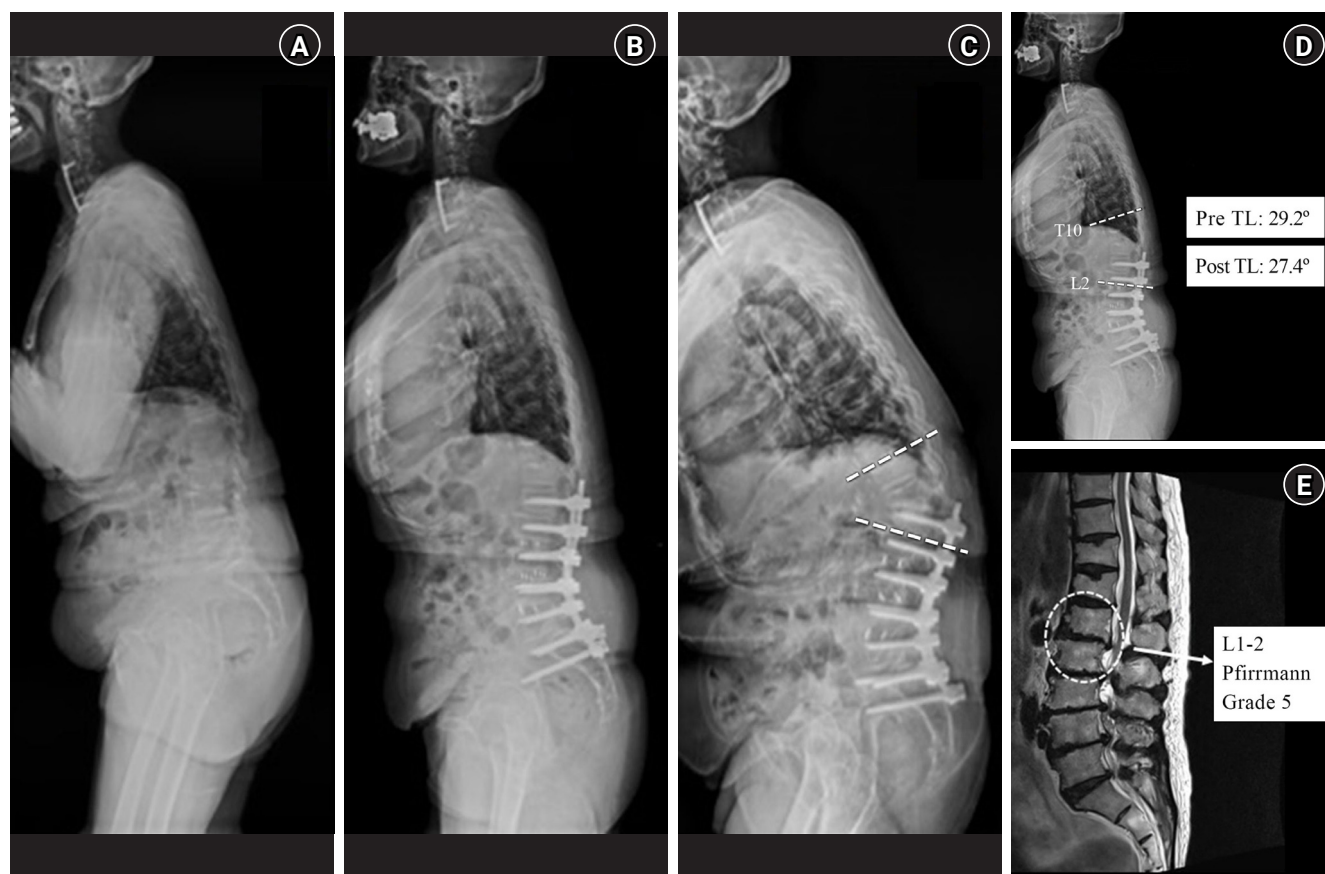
Representative case of early proximal junctional kyphosis (PJK) in a 72-year-old woman with a stooping gait. (A) Preoperative standing lateral radiograph demonstrating degenerative flatback deformity. (B) Immediate postoperative radiograph following multi-level thoracolumbar fusion. (C) Follow-up radiograph obtained 3 months postoperatively demonstrating early PJK, with dashed lines indicating the increased proximal junctional angle. (D) Postoperative standing lateral radiograph with annotated T10–L2 Cobb angle measurement, demonstrating persistently elevated thoracolumbar kyphosis (preoperative TL angle: 29.2° ; postoperative thoracolumbar [TL] angle: 27.4°). (E) Preoperative sagittal magnetic resonance imaging demonstrating advanced degeneration of the L1–2 intervertebral disc (Pfirrmann grade V, dashed circle).
